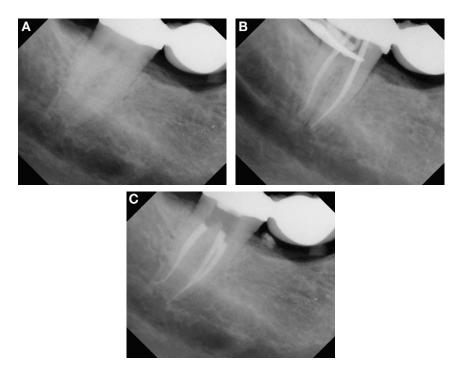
(A) Before making access, it is essential to radiograph the tooth from multiple angles (only the straight buccal is shown). (B, C) Subsequent treatment with the K3 system.
